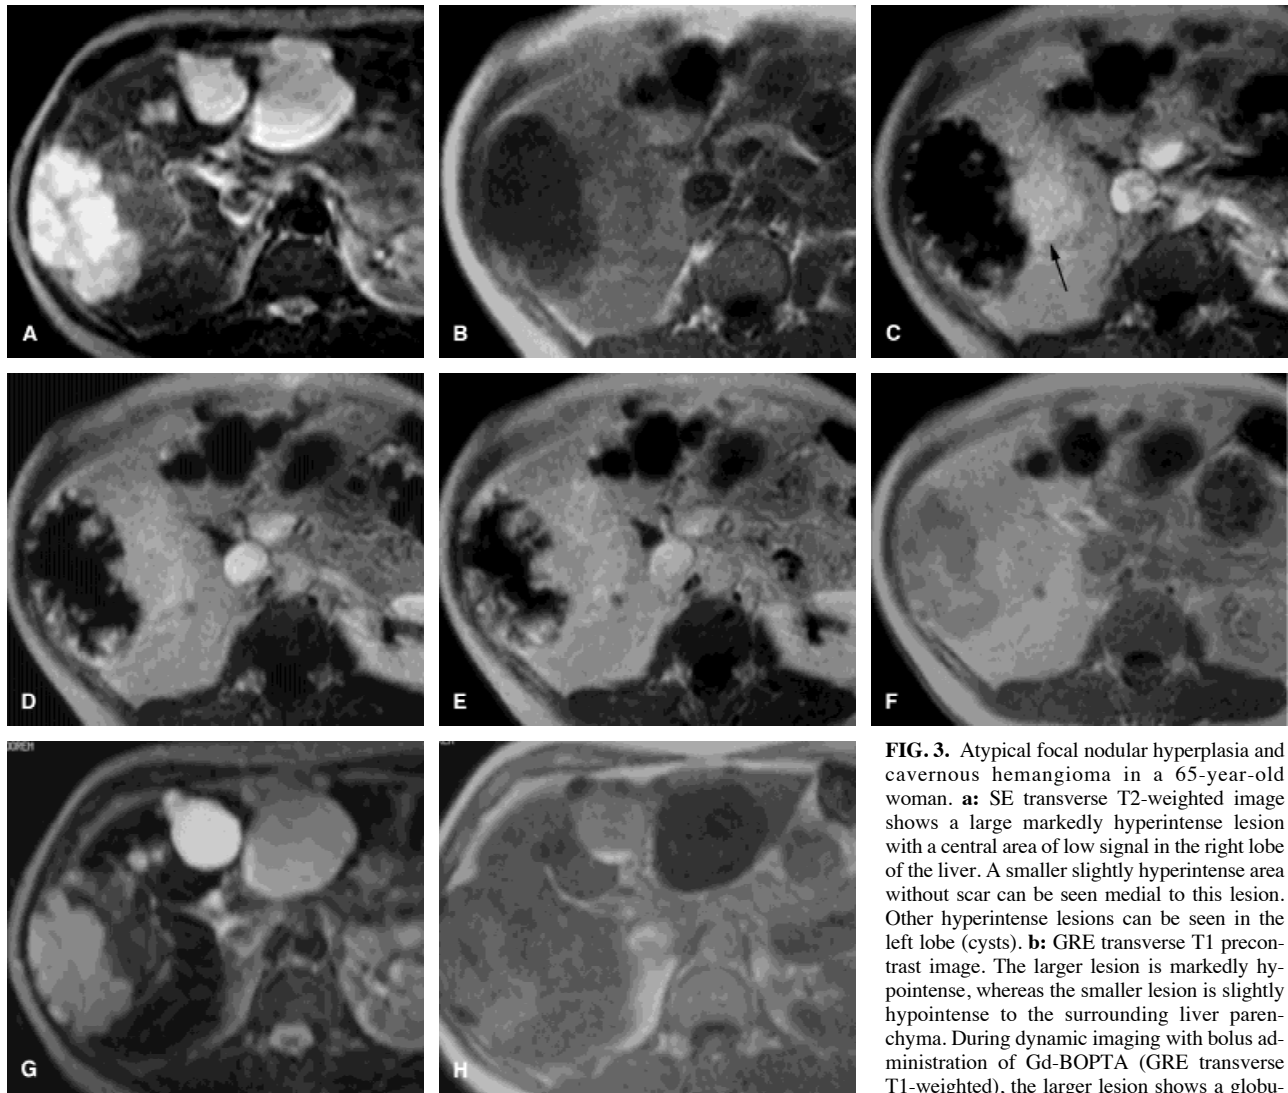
Atypical focal nodular hyperplasia and cavernous hemangioma in a 65-year-old woman. a: SE transverse T2-weighted image shows a large markedly hyperintense lesion with a central area of low signal in the right lobe of the liver. A smaller slightly hyperintense area without scar can be seen medial to this lesion. Other hyperintense lesions can be seen in the left lobe (cysts). b: GRE transverse T1 pre-contrast image. The larger lesion is markedly hypointense, whereas the smaller lesion is slightly hypointense to the surrounding liver parenchyma. During dynamic imaging with bolus administration of Gd-BOPTA (GRE transverse T1-weighted), the larger lesion shows a globular peripheral enhancement, whereas the smaller
